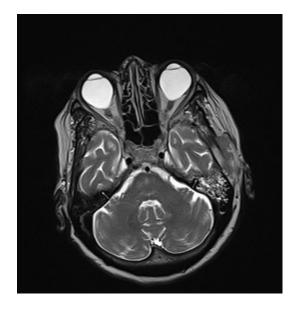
T2 TSE MRI image of the brain.
